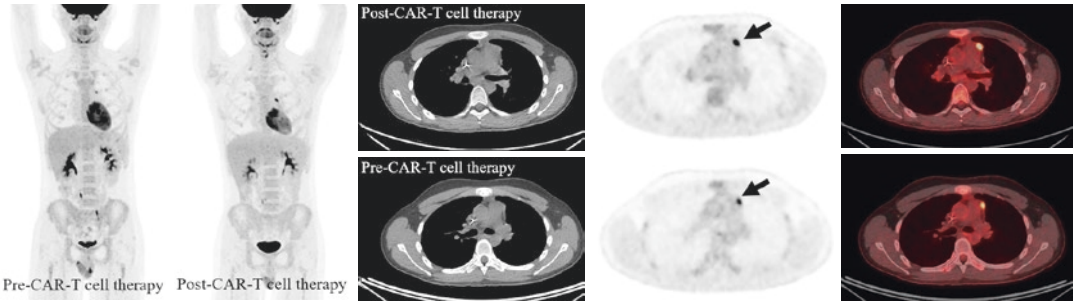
46-year-old man with diffuse large B cell lymphoma. Prior to CAR-T cell therapy, FDG-avid lymphoma was seen in a 1.3 × 0.5 cm anterior mediastinal soft tissue density with SUVmax 5.2 (arrow). Post-CAR-T cell therapy, the FDG-avid anterior mediastinal soft tissue
